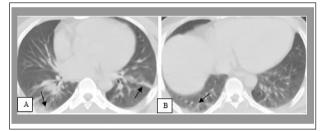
Axial chest CT images at discharge (A, B) show prominent regression in the pneumonic infiltrations. Some persistent subpleural densities at lung bases were noted (A, B; black arrows).
